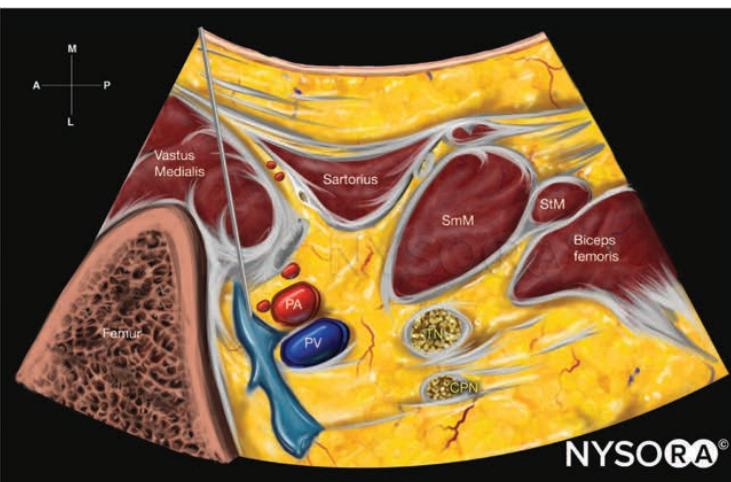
iPACK block reverse ultrasound anatomy with needle insertion in-plane. SmM, semimembranosus muscle; StM, semitendinosus muscle; PA, popliteal artery; PV, popliteal vein; TN, tibial nerve; CPN, common peroneal nerve.
